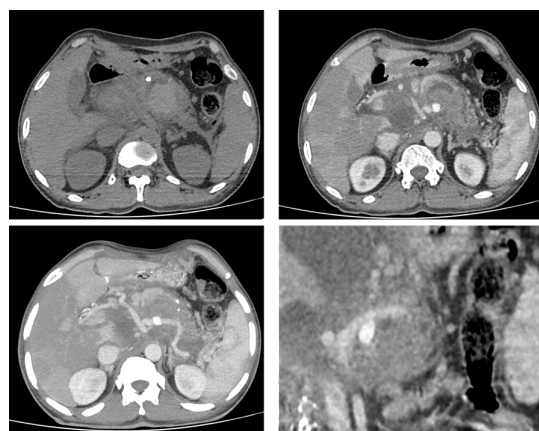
a- Non contrast axial; b & d- Contrast enhanced axial and coronal CT images showing Acute on chronic pancreatitis with pseudoaneurysm of splenic artery (Arrow)
